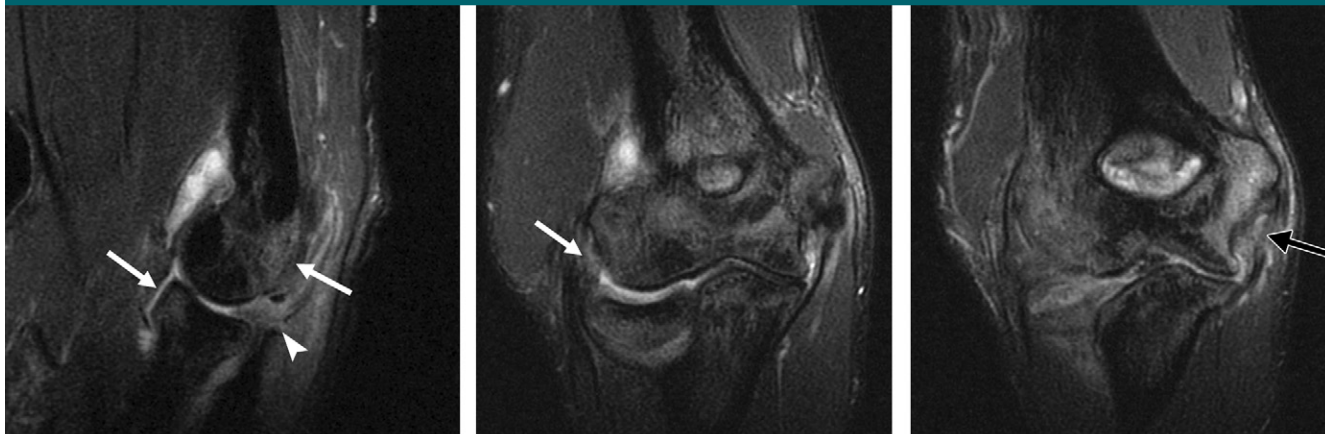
(a) Sagittal T2-weighted FS MR image of the elbow in a 21-year-old man with recent posterior dislocation demonstrates characteristic “kissing contusions” on the posterior capitellum and anterior radial head (arrows) and disruption of the posterior joint capsule (arrowhead). There is also posterior subluxation of the radial head indicating a LUCL injury. (b, c) Coronal T2-weighted FS MR images show complete tears of the proximal LUCL (white arrow) and midfibers of the anterior band of the MCL (black arrow), with diffuse bone marrow edema.
